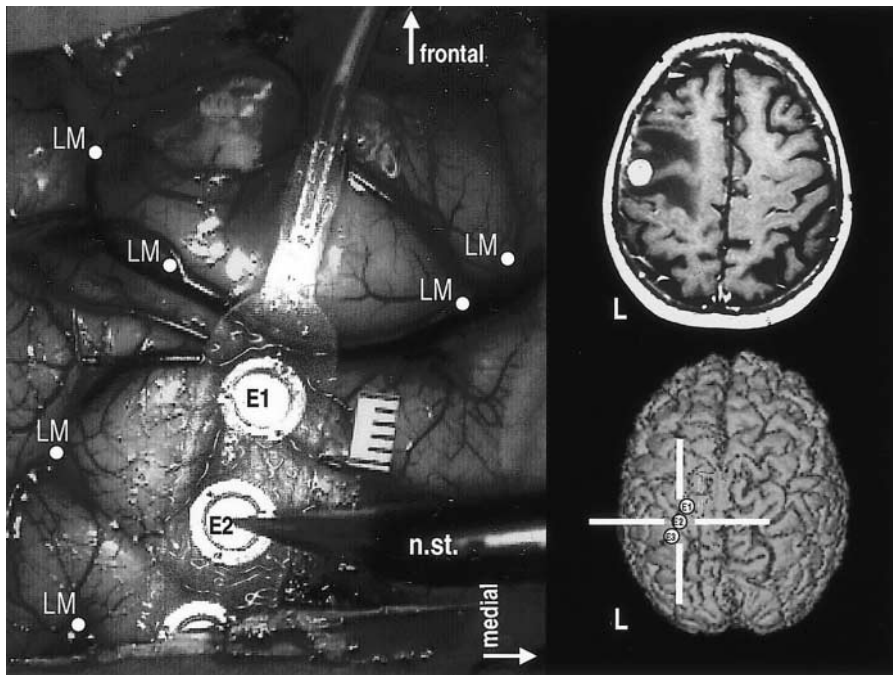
Following placement of the strip electrode, the Cartesian coordinates of both the stimulating electrodes ( $E1$ ,  $E2$  . . .) and of superficial cortical landmarks ( $LM$ ) are registered. The spatial positions are indicated by colored points on the 3D brain model of the navigation system. Axial CT, vertically mirrored for better orientation relative to the 3D model.  $L$  Left  $n.st.$  navigation stylus
